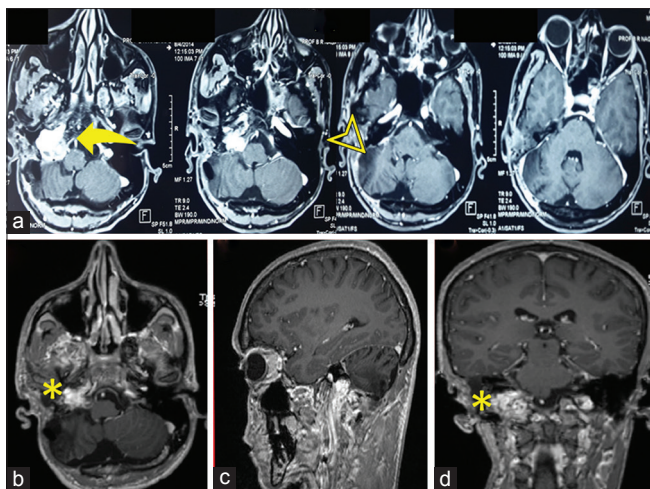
Postoperative images of patient 2: (a) Postoperative magnetic resonance imaging axial images showing residual lesion in the petrous bone (arrow) and complete excision of the intracranial (arrow head) and extracranial components of the lesion. (b-d) (axial, sagittal, and coronal cuts, respectively) showing reduction in tumor size following gamma knife irradiation (asterisk)
